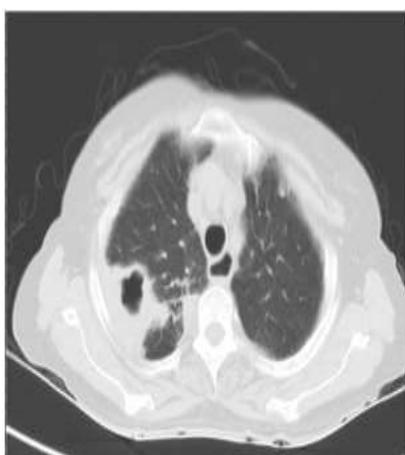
Axial section of CT Thorax revealing cavity lesion with surrounding consolidatory changes in right upper lobe posterior segment and patulous oesophagus
